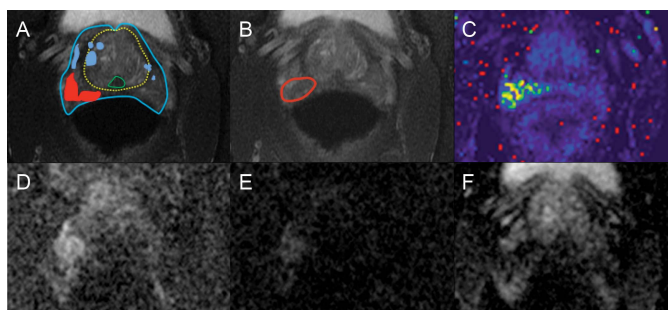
Tumor outline on pathology (A) registered to tumor outlined on mp-MRI (B). There is overlap for high grade tumor (red area in A) and no overlap for lower grade tumor (blue areas in A). Overlap with significant tumor was 36% in this case. B = T2w, C = DCE, D = B800 DWI, E = B1600 DWI, F = ADC map
